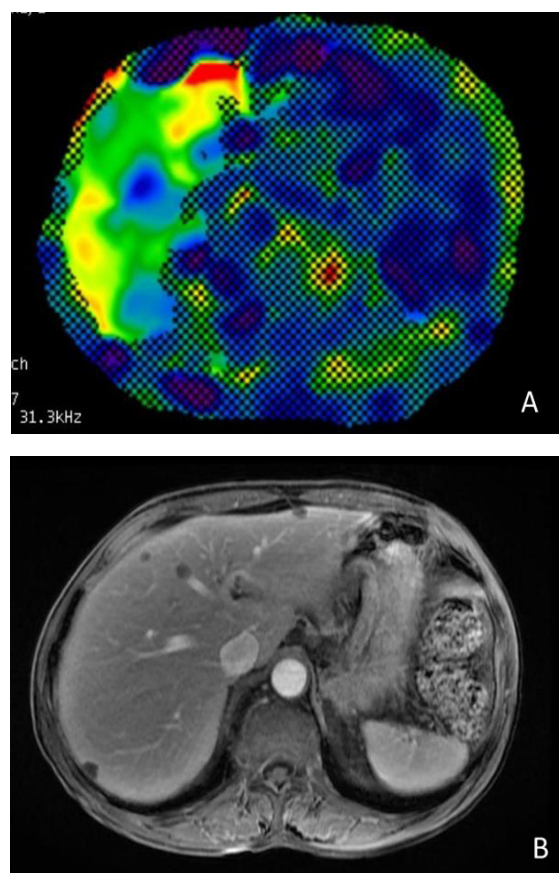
Hepatic parenchyma and liver stiffness. (A) Magnetic resonance imaging shows the liver with a normal hepatic parenchyma. (B) Magnetic resonance elastography shows the stiffness map (elastogram) produced by an inversion algorithm that processed the information in the wave image.
